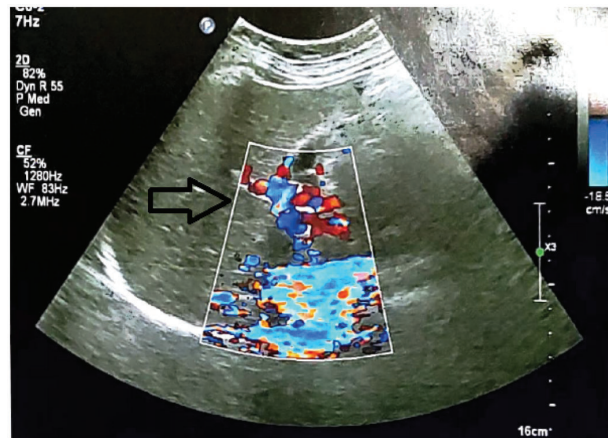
Doppler Ultrasound of portal and hepatic vein
